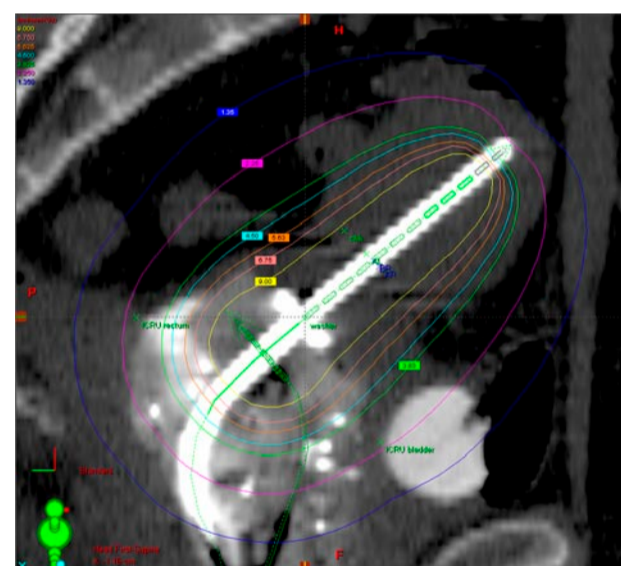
Sagittal CT scan through centre of applicator to demonstrate both ICRU Rectal and Bladder Points
